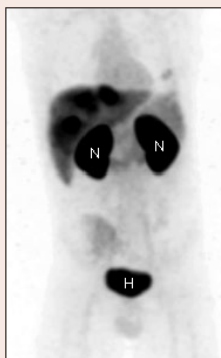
Im 68Gallium-PSMA-PET finden sich drei größere Lebermetastasen; N = Niere, H = Harnblase
